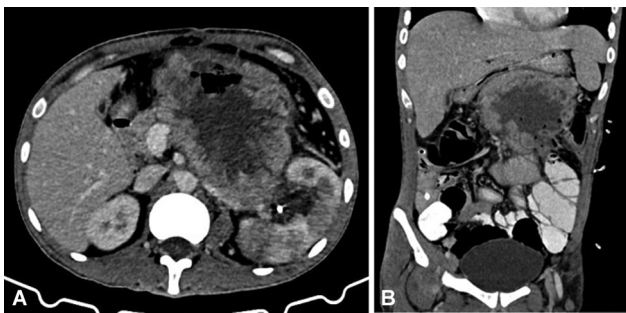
(A) CT image with cross-sectional view of jejunal mass. (B) CT image with coronal view showing jejunal mass.
